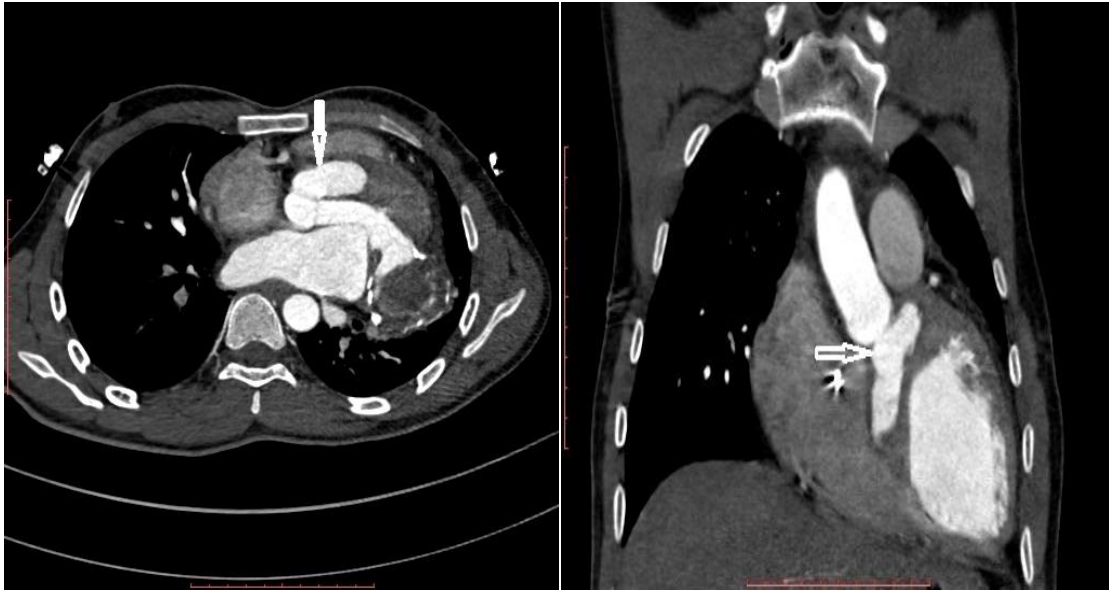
2B. Contrast cardiac CT showing the aneurysm in the axial and coronal view (marked by an arrow)
